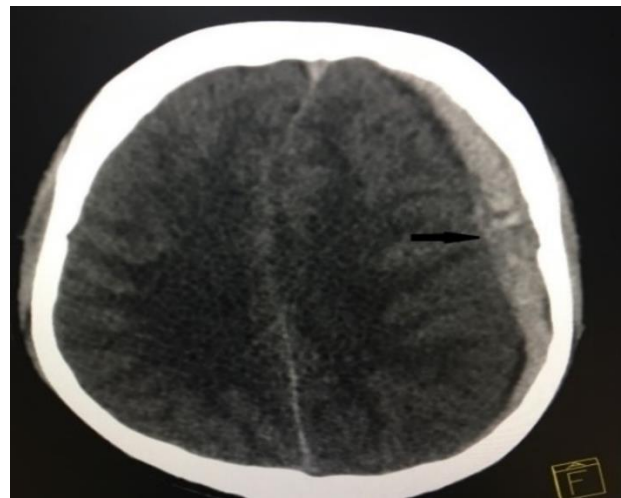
Computed tomography brain axial section upper cuts showing hyperdensity at the left subdural region marked with arrow suggestive of left subdural hematoma.
